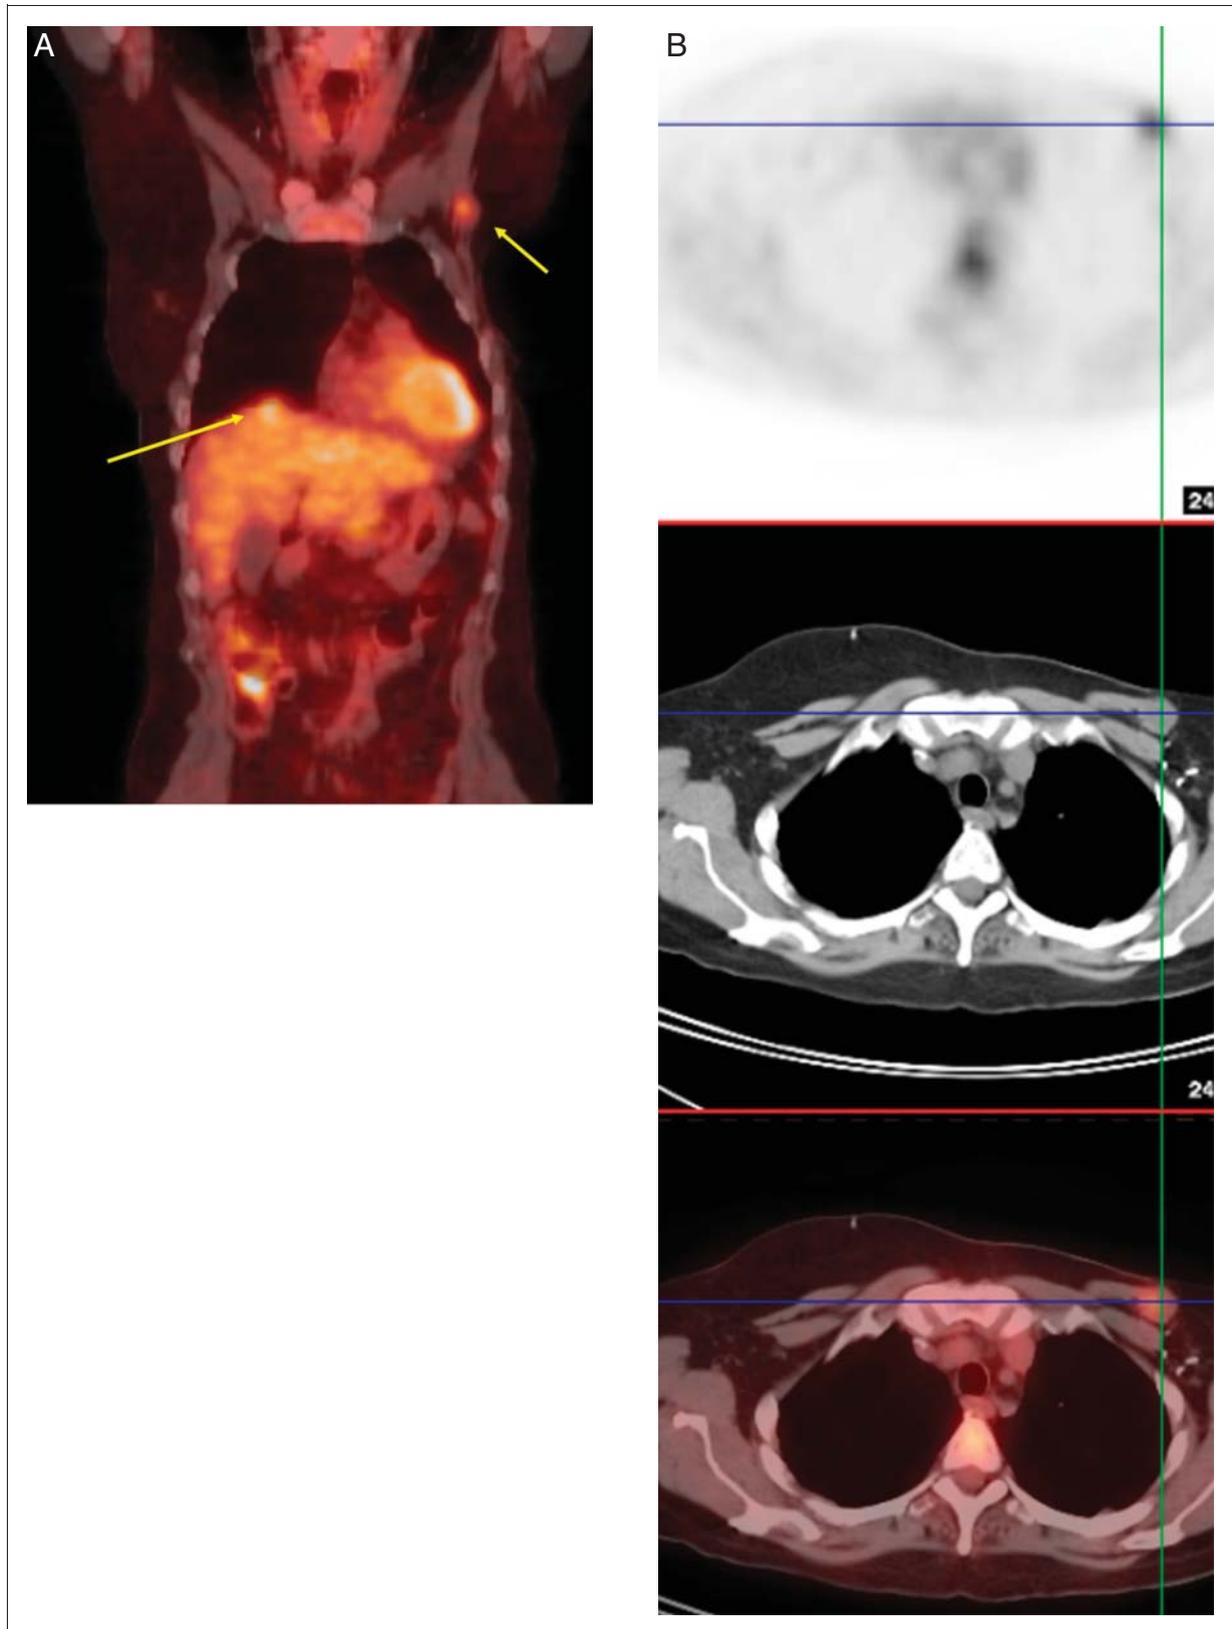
FDG PET/CT detection of breast cancer local recurrence and distant disease. (A) Fusion PET/CT image coronal view demonstrating local recurrence of breast cancer in the left chest wall and in the liver, both of which were not detected on CT alone; (B) top to bottom: FDG-PET, CT, and fusion PET/CT coregistered transaxial images demonstrating left chest wall recurrence.
